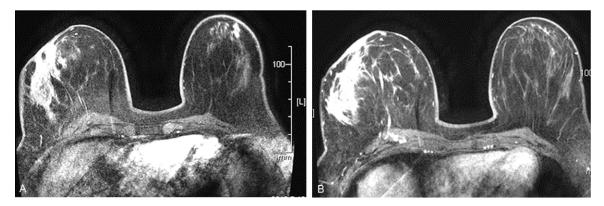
MRI plain-scan images of a 24 year-old female with MDE complicated with inflammation and granuloma obtained (A) before contrast medium injection and (B) after contrast medium injection. The lesion exhibits patchy and irregular enhancement, with clear boundaries, although the edge was not smooth.
